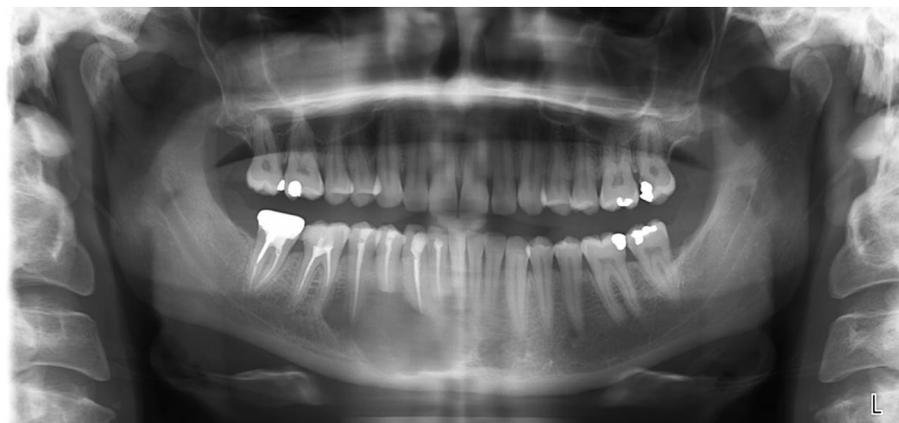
Orthopantomogram. Osteolytic lesion of the horizontal branch of the mandible with root resorption of 43, 44, and 45.
